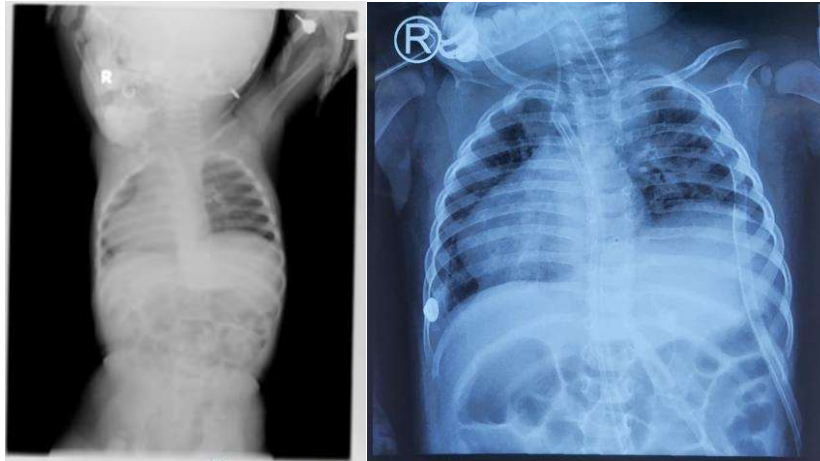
Pre-operation babygram, both diaphragms normal (Left), Chest x-ray post open-heart surgery, left diaphragm appears to be elevated (Right)
